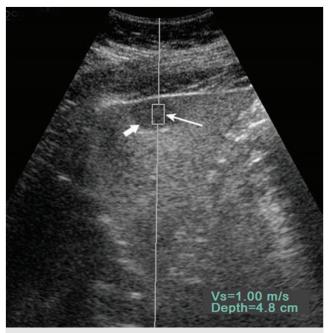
Acoustic radiation force impulse (ARFI) technique for shear wave elastography (SWE). Measurement of velocity of shear wave within the ROI (*long arrow*) of a hypoechoic focal liver mass (*short arrow*) with underlying fatty liver of a 29-year-old woman. This mass is confirmed as a hemangioma on following contrast-enhanced ultrasound. V_s = velocity of shear wave. Depth indicates the distance from the skin to the center of the ROI.
